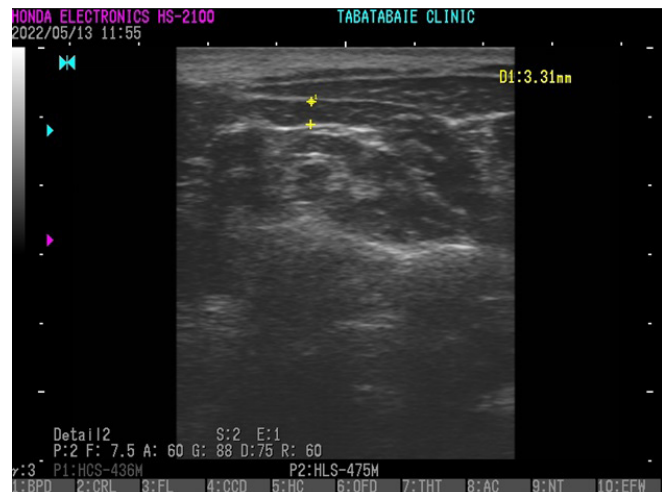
Semispinalis capitis muscle size via ultrasonography.
